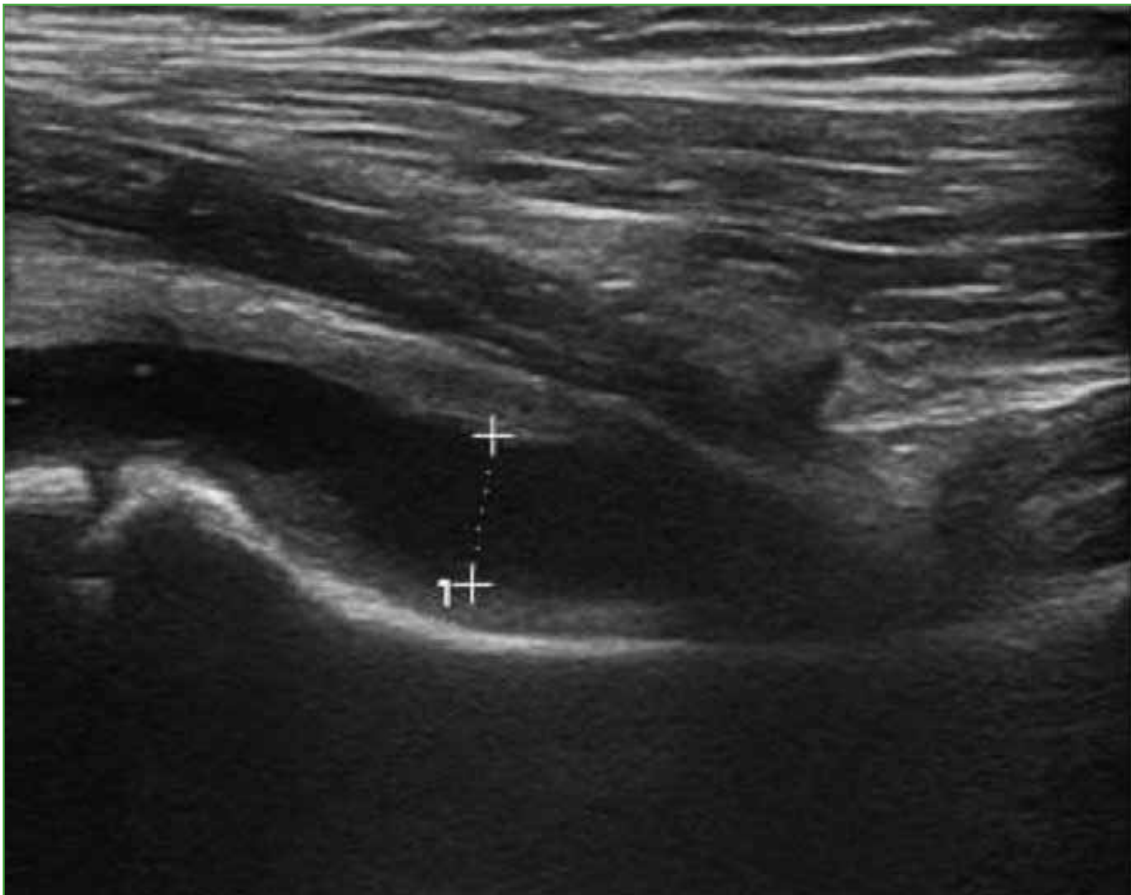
Hip ultrasound showing a right joint effusion with a detachment of 7 mm from the joint capsule, with intact muscle planes.
